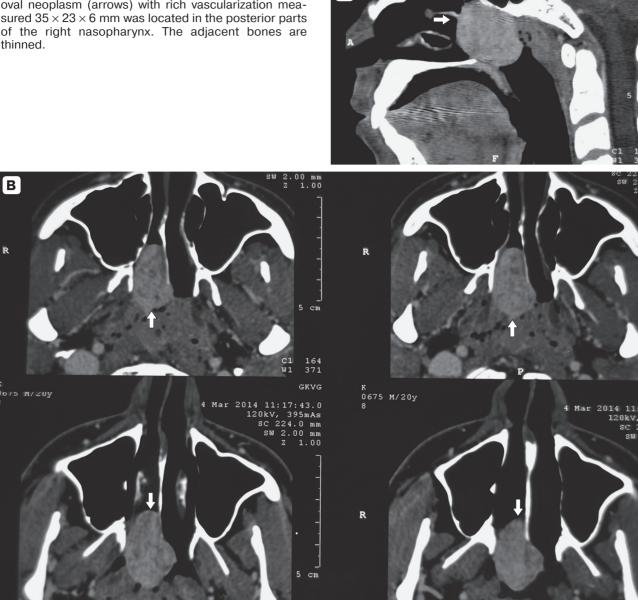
Angiofibroma (arrow) of the posterior regions of the right half of the nasopharynx (contrast enhanced CT).
